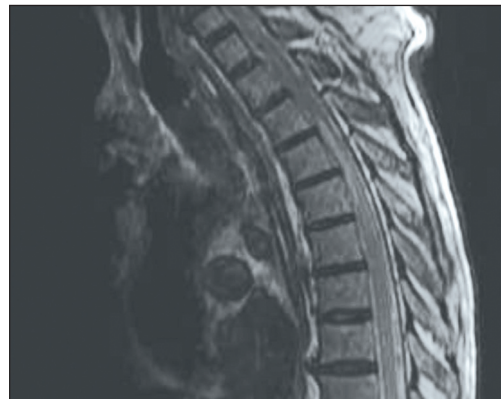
Lumbar magnetic resonance imaging t1 sequence-A significant spinal expansion and edema appearance was detected in the upper thoracic segments.
